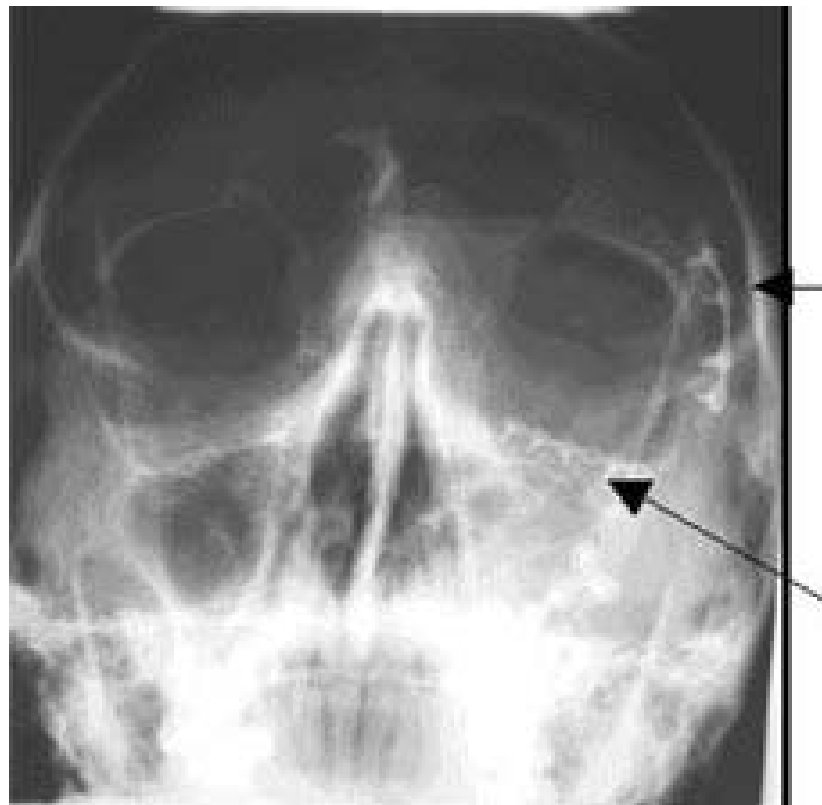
Control Water's radiograph, osteosynthesis at the FZ suture and IOR
